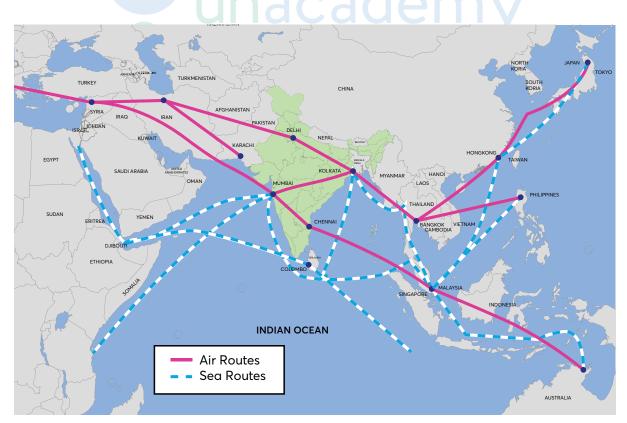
LOCATION OF INDIA WITH RESPECT TO TRADE ROUTES WITH NEIGHBOURING REGIONS
